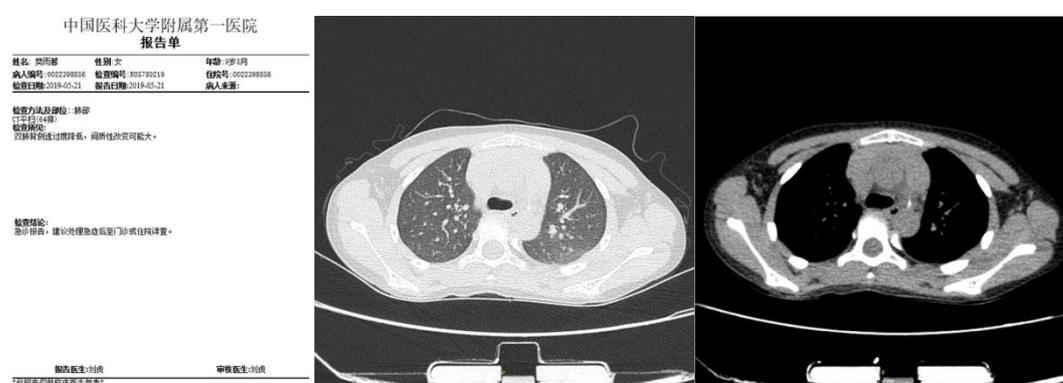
Chest CT report and representative pictures suggest no nodules in chest (2019-5-21)
